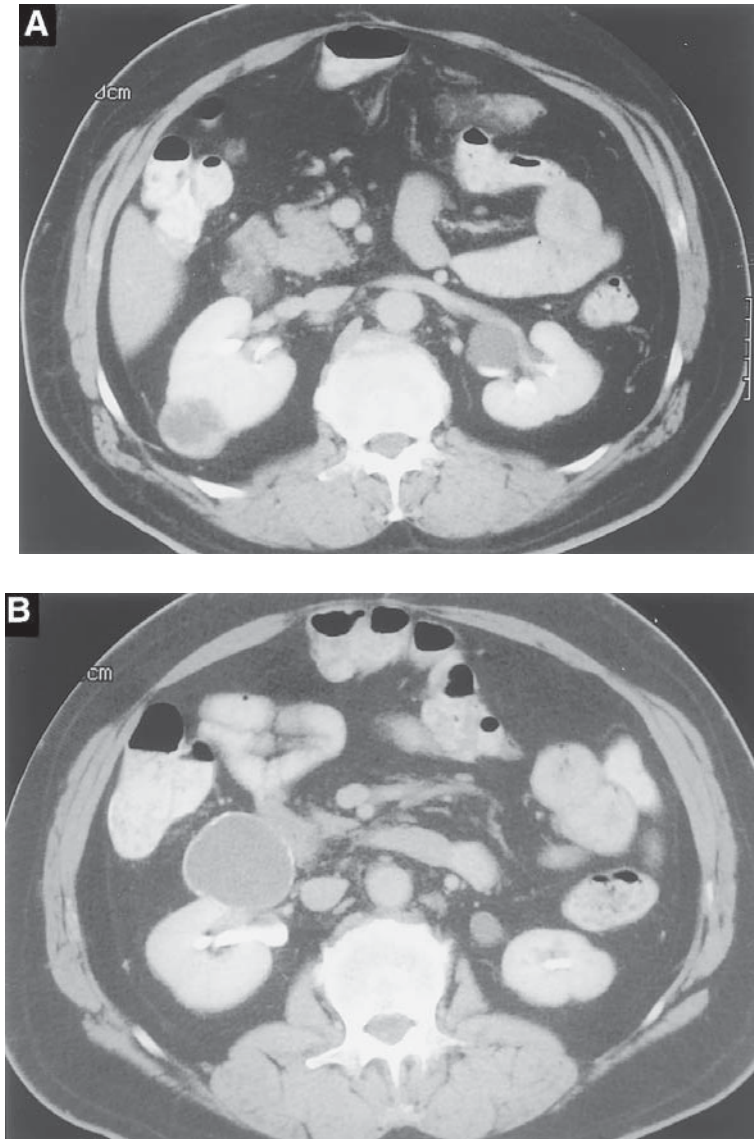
CT scan of a kidney with two cystic lesions (A and B) at opposite poles. Although aspiration biopsy of each mass was negative for tumor, nephron-sparing surgery was performed, and renal cell carcinoma was found in each mass.
